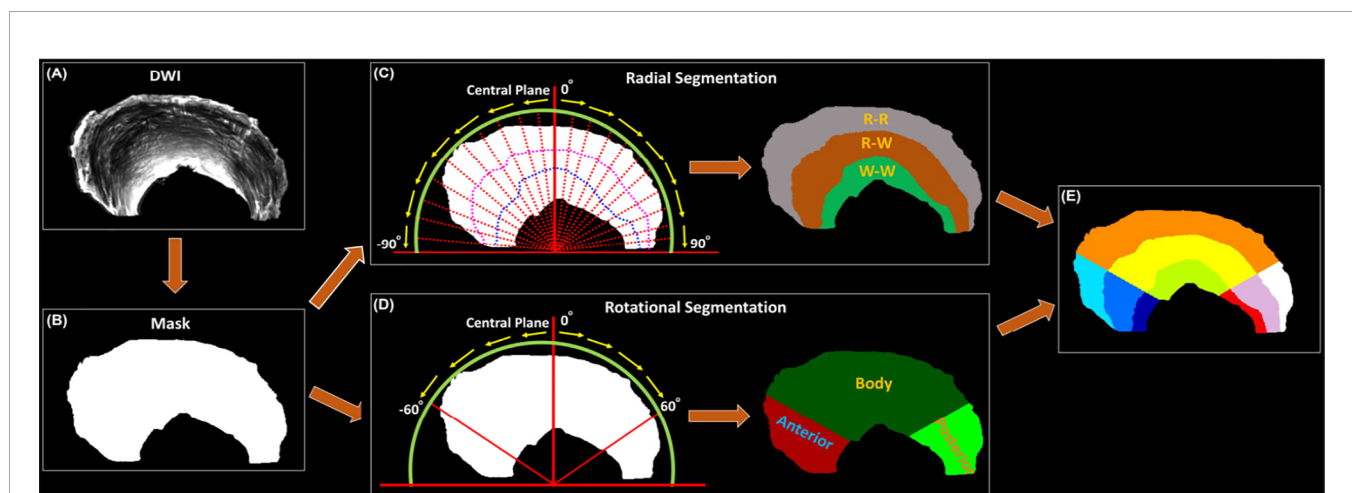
The automatic segmentation process used in this study, from the acquired DWI (A) to the 9 different areas of meniscus (E). Both Radial Segmentation (C) and Rotational Segmentation (D) were derived from the binary mask (B). These two methods were further combined to divide the whole meniscus to 9 regions (E). R-R, Red-Red zone; R-W, Red-White zone; W-W, White-White zone.
